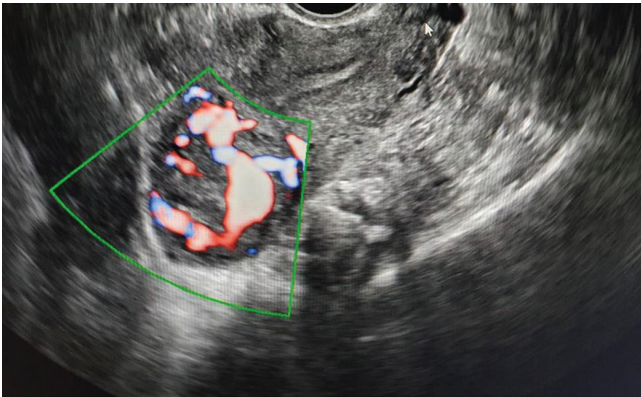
Follow-up transvaginal ultrasound 3 weeks post methotrexate therapy showing moderate color doppler flow in left complex adnexal mass
